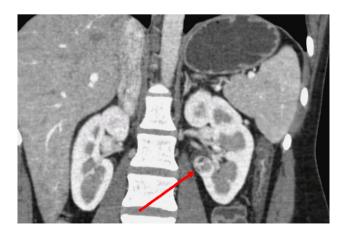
Hilar tumor. Computed tomography demonstrates a 2.6-cm solid tumor located near the left renal vessels and abutting the renal pelvis.
